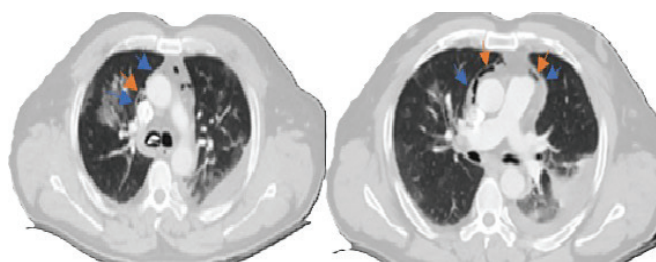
Thoracic CT scan obtained on the 5th day after trauma (Blue arrows: pericardial border, red arrows: pneumopericardium).
